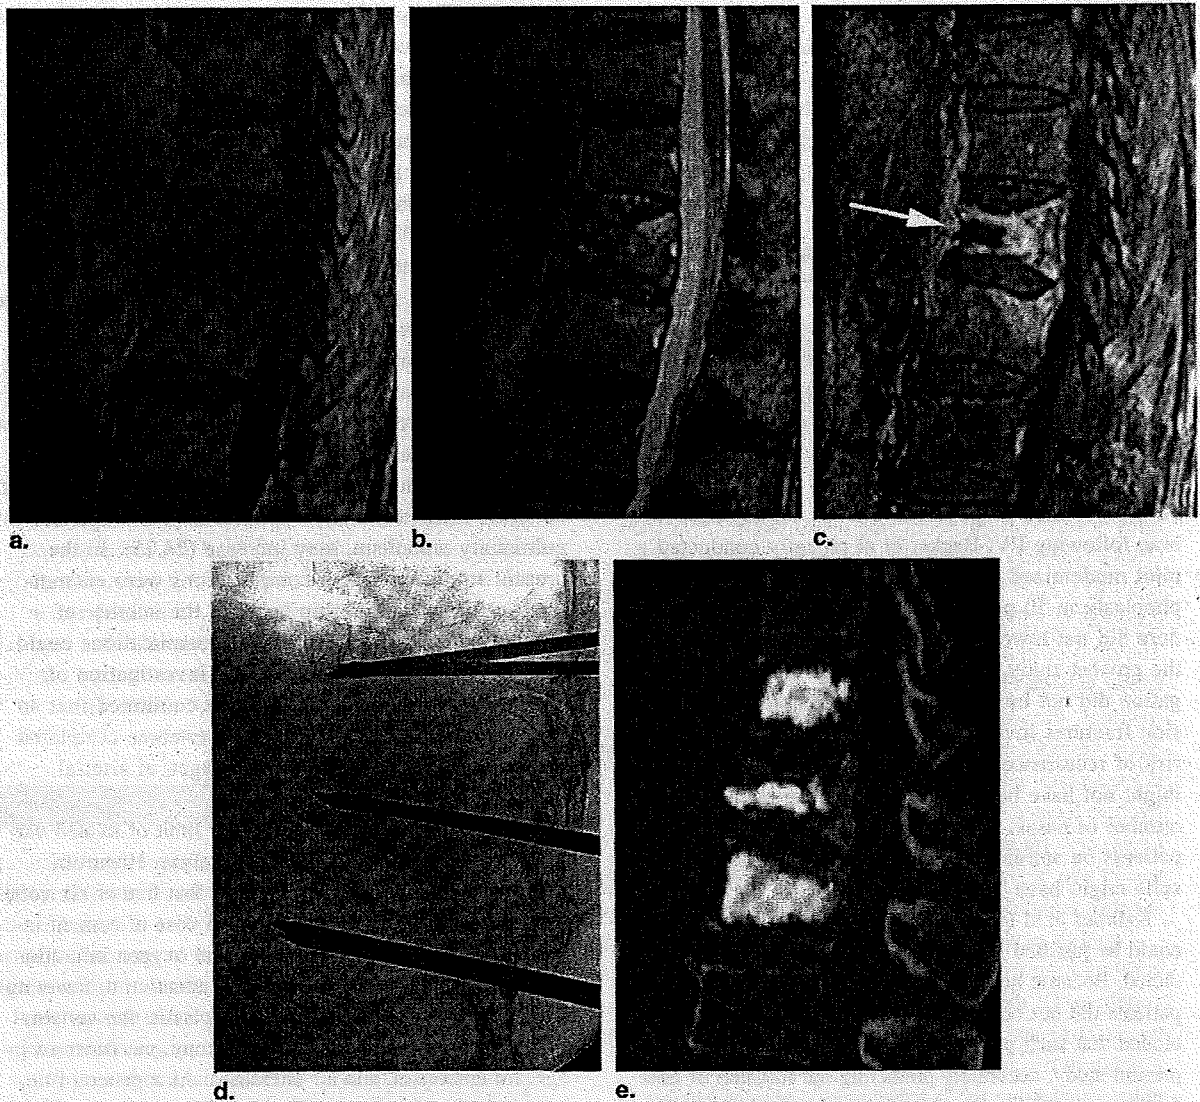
(a) T1-weighted, (b) fat-suppressed T2-weighted, and (c) fat-suppressed contrast-enhanced T1-weighted sagittal images of a 79-year-old man with osteoporotic compression fractures of L1 and L2 vertebrae. There is an unenhanced portion in L1 vertebral body indicating a cleft (*white arrow*). (d) Lateral fluoroscopic image showing 11-gauge needles inserted into the fractured vertebrae (L1, L2) and into a non-fractured vertebra (Th12) as prophylactic treatment. (e) Sagittal reconstructed computed tomography showing cement in the fractured vertebrae (L1, L2) and in the upper adjacent non-fractured vertebra (Th12).
